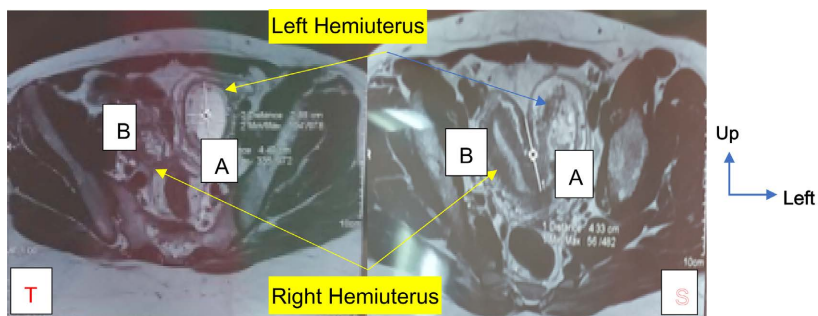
MRI image of bicornuate uterus with trophoblastic retention (A) in the left hemi horn and empty right hemi horn (B), cross section (T); sagittal section (S) (Pictures Hôpital Principal de Dakar).
